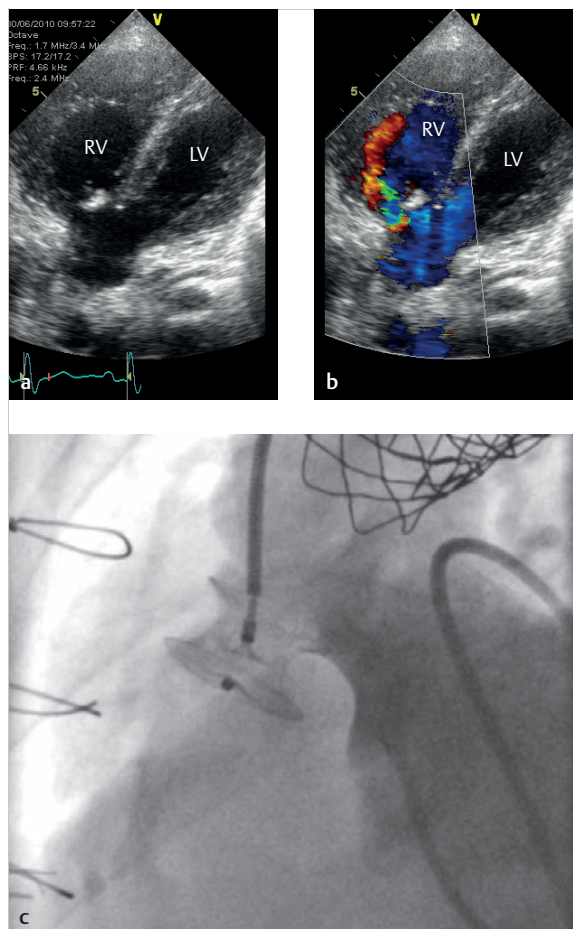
Combination with ultrasound and angiography. Echocardiographic and angiographic depiction of a VSD closure. LV = left ventricle
